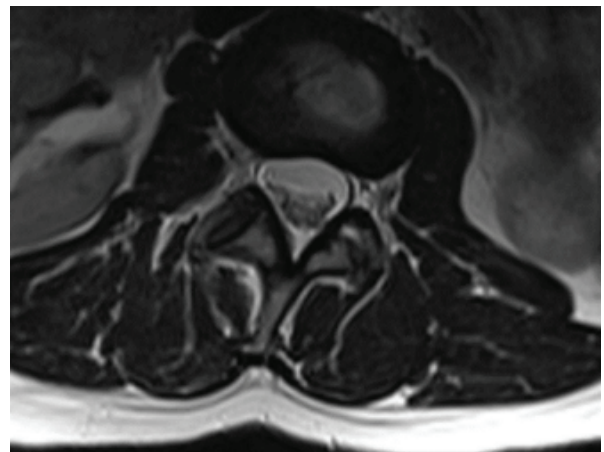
T2-weighted LS MRI scan shows acute spinal subdural hematoma at the level of L2 vertebral body.
